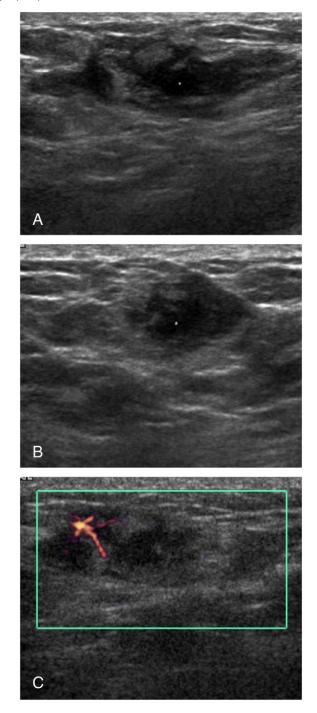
Transverse (A) and longitudinal (B) ultrasonography images show a 3.5×1.0 cm heterogeneous echoic mass with an internal anechoic portion (asterisk in A and B) predominantly located in the subcutaneous fat layer, abutting the medial end of the breast parenchyma. The color Doppler image (C) demonstrates increased focal intralesional vascularity.
